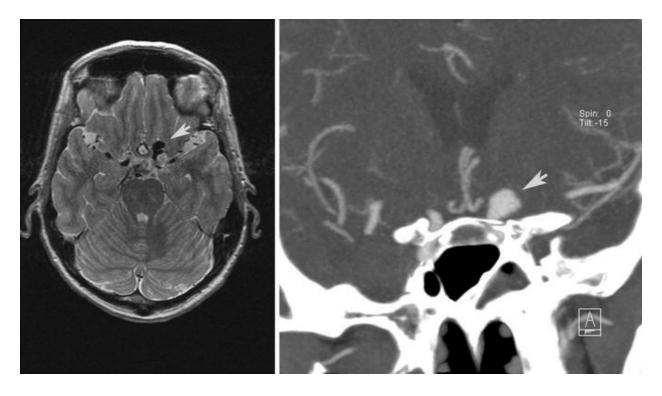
Example of incidentally discovered aneurysm. T2w MR research scan (*left*) acquired in a 57-year-old female Rotterdam Study participant shows an aneurysm of the left intracranial internal carotid artery. After hospital referral for further workup, CT angiography (*right*) confirmed a 9 mm carotid tip aneurysm. The aneurysm was coiled successfully
